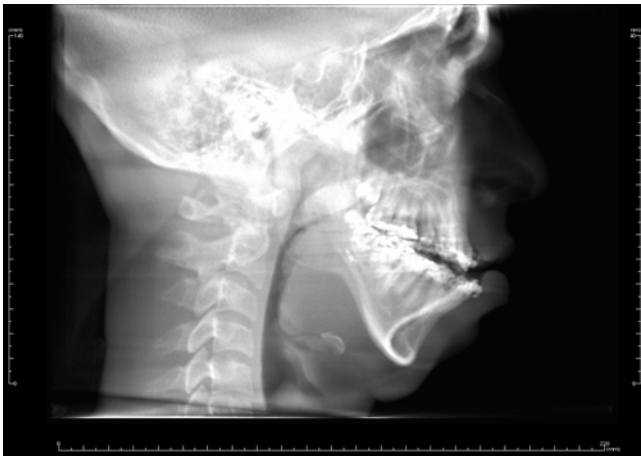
Traditional lateral cephalometric skull image extracted from a CBCT scan
